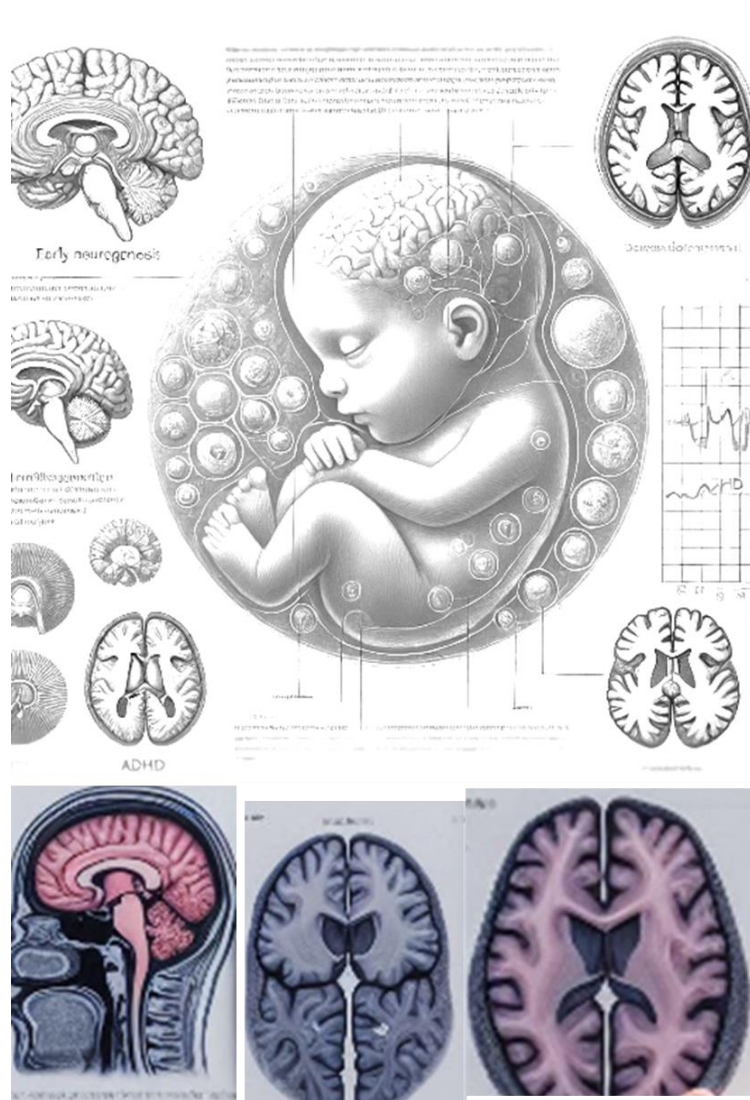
Overview of Fetal Brain Development and MRI Techniques
